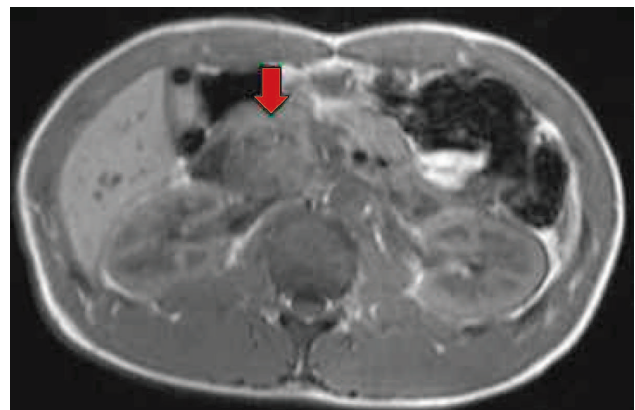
Fat-suppressed T1-weighted magnetic resonance (MR) image shows a hypointense mass in the pancreatic head (red arrow) relative to adjoining normal pancreatic parenchyma.
